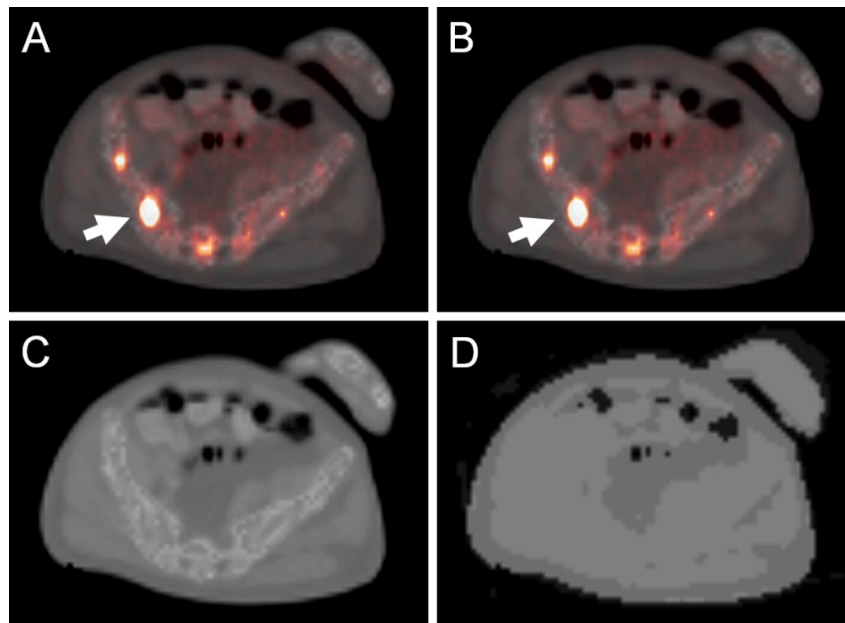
Lesion in the pelvic bone (arrow) which showed the largest SUV variation (13%) when reconstructed using a segmented attenuation map. It is difficult to note any visual differences. a) Original PET/CT image. b) PET image reconstructed using a segmented attenuation map fused to the original CT. c) CT-based attenuation map. d) Segmented attenuation map used to reconstruct image (b). Image reprinted by permission of the Society of Nuclear Medicine from [184].
